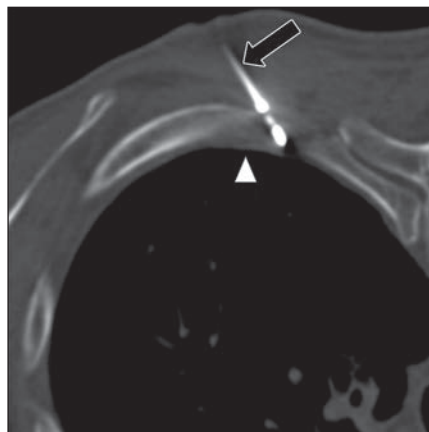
Cryoablation for postthoracotomy pain syndrome in 45-year-old man. Axial procedural CT of chest shows cryoprobe (*arrow*) at inferior rib margin, positioned just short of pleural line (*arrowhead*).
